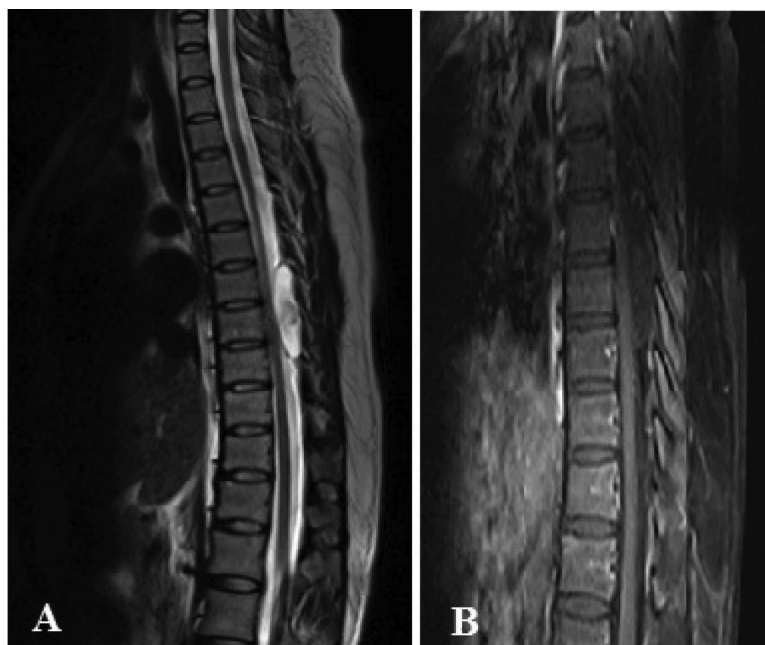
Pre-operative spinal MRI shows a cystic lesion extending from T7 to T9 with hyper intense signal on T2-weighted MRI accompanied by a central hypo intense signal (A). Pre-operative contrast enhanced T1-weighted MRI shows non-enhancing hypo intense lesion extending from T7 to T9, with signal intensity similar to cerebrospinal fluid (B).
